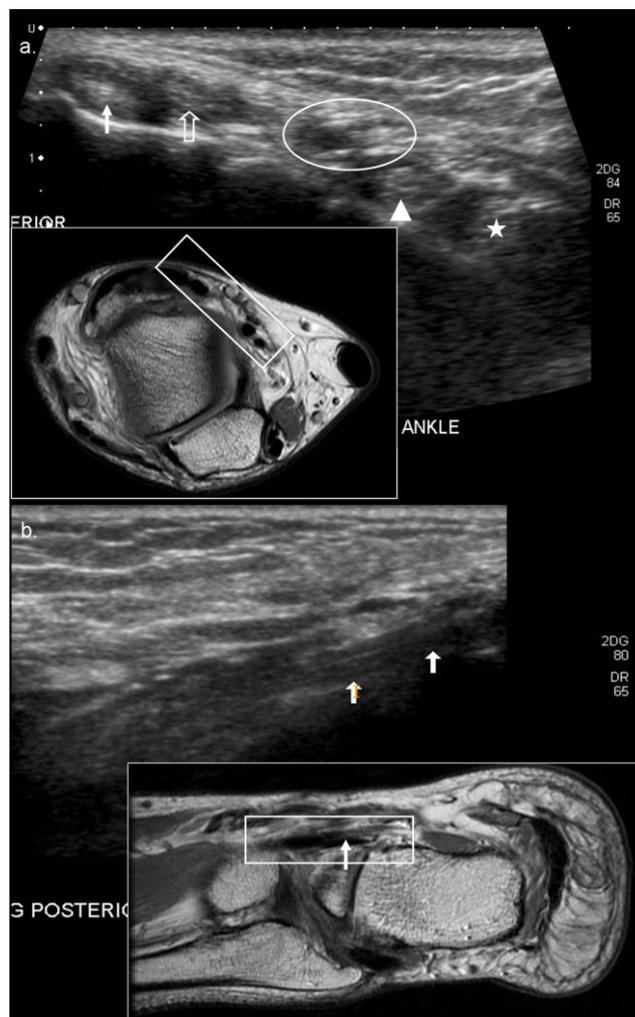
(right): 68-year-old male with ankle pain and an accessory peroneocalcaneus internus muscle. A. The inset image is a rotated, non-contrast, axial, proton density FSE MR image (3T GE clinical scanner, GE Healthcare, WI, USA; TR=3707, TE= 29, ETL=8, matrix 384x256, FOV=14cm, slice thickness/spacing=4/0mm). The white rectangle on the inset MR image demonstrates the field of view and orientation of the provided ultrasound image (Toshiba Aplio XG, 12 (7-14) MHz linear array transducer; Toshiba America Medical Systems, Inc., Tustin, CA). Tibialis posterior tendon (white arrow). Flexor digitorum longus tendon (open arrow). Tibial neurovascular bundle (outlined white oval). Flexor hallucis longus tendon (arrowhead). Accessory muscle tendon (star). B. Longitudinal ultrasound of the medial right ankle at the level of the tibiotalar joint. The inset image is a rotated, non-contrast, coronal proton density FSE MR image (3T GE clinical scanner, GE Healthcare, WI, USA; TR=4946, TE= 29, ETL=8, matrix 384x256, FOV=14cm, slice thickness/spacing=3/0mm). The white rectangle on the inset MRI demonstrates the field of view and orientation of the provided ultrasound image outlining the location of the ultrasound image (Toshiba Aplio XG, 12 (7-14) MHz linear array transducer; Toshiba America Medical Systems, Inc., Tustin, CA). The accessory muscle tendon of the medial ankle (arrows) is seen posterior and lateral to the flexor hallucis longus tendon (arrowhead).
